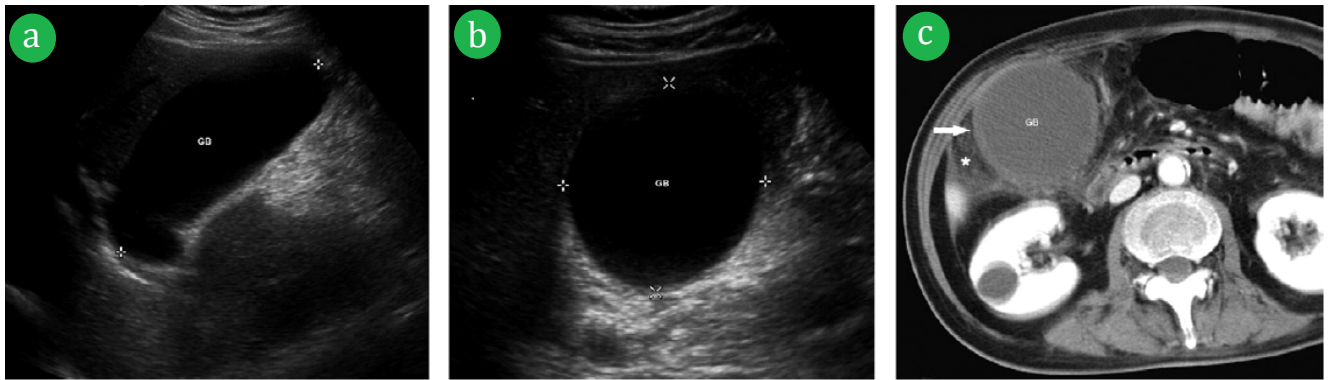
(a, b). Longitudinal and horizontal ultrasound of a 64-year-old man with positive Murphy's sign, showing hydrops. (c). CT scan 6 hours later showing thickened gallbladder wall (white arrow), hydrops and pericholecystic inflammation (asterisk).
